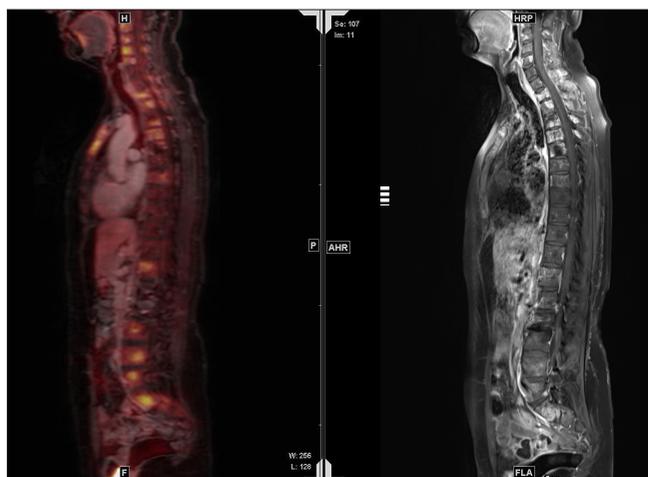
a, b. A 35-year-old patient with grade 3 invasive ductal carcinoma of the left breast. Fused PET/MR and sagittal Dixon T1W MR images (a, b) both show similar metastatic lesions
